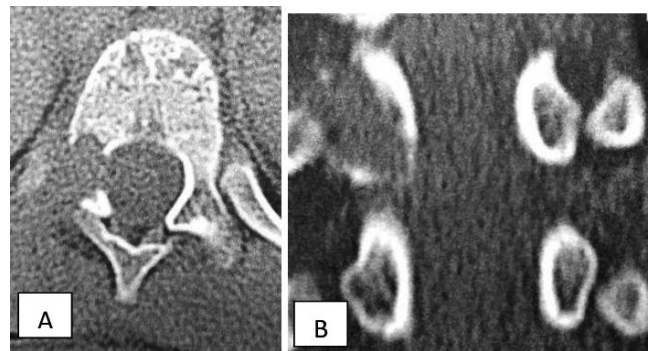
Imaging at the first year. (A) Axial spine computed tomography and (B) coronal spine computed tomography, without radiological signs of lesion recurrence.
